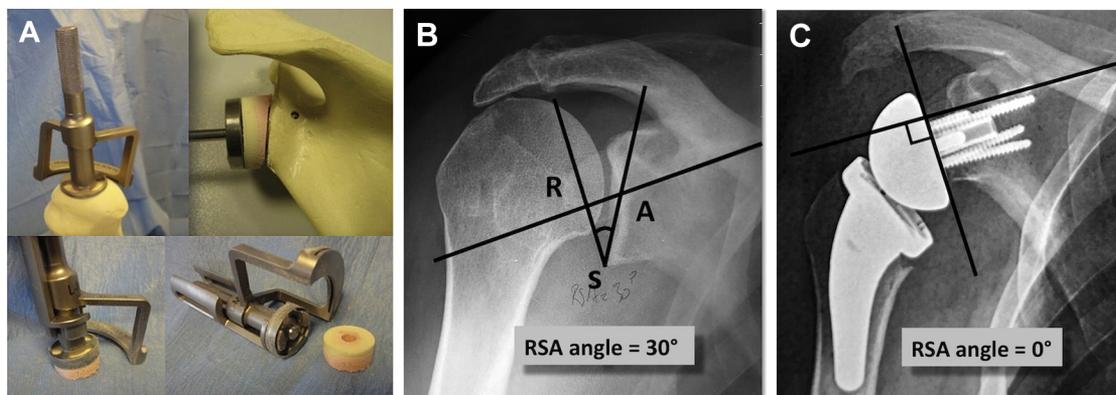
Use of BIO-RSA to lateralize and correct superior glenoid inclination: (A) Asymmetrical inferior reaming combined with an inferiorly angled bone graft, harvested from the humerus with an angled cutting guide, is used to achieve neutral inclination of the baseplate and glenosphere (ie, to correct the RSA angle). (B, C) Preoperative and postoperative radiographs demonstrate correction of the reverse shoulder arthroplasty (RSA) angle with neutral tilt of the baseplate and sphere after angled BIO-RSA.
